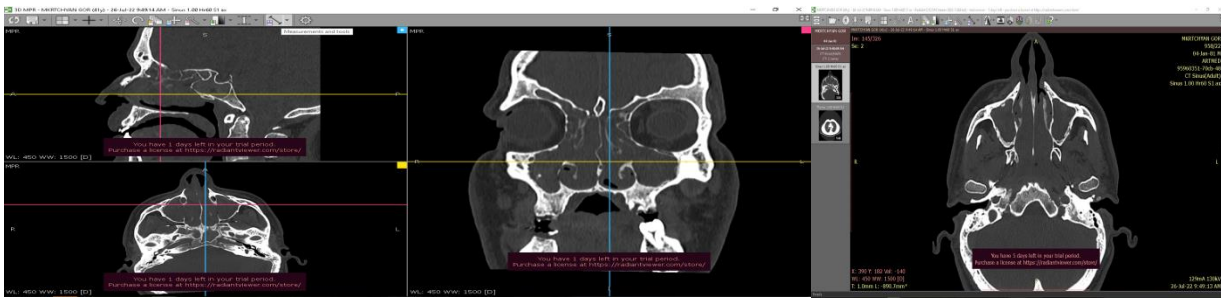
CT shows a liquid in the maxillary sinus
